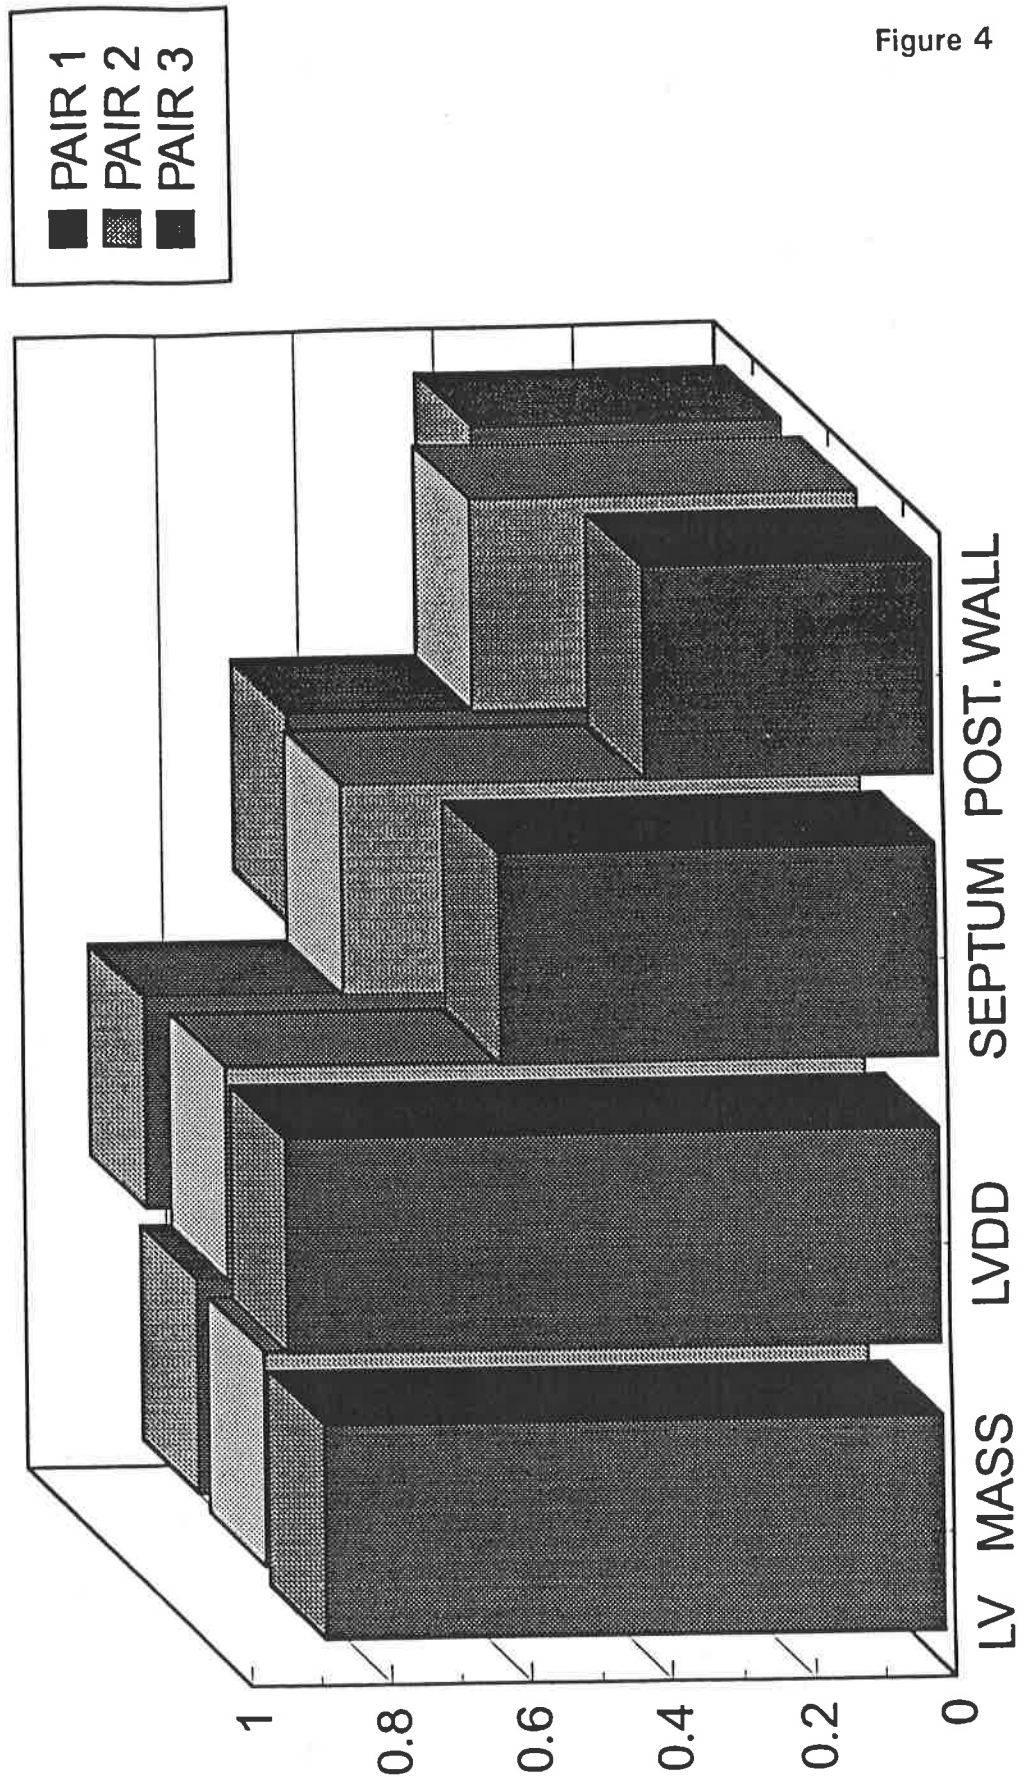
Echocardiographic Components of LV Mass: Interobserver Variability
